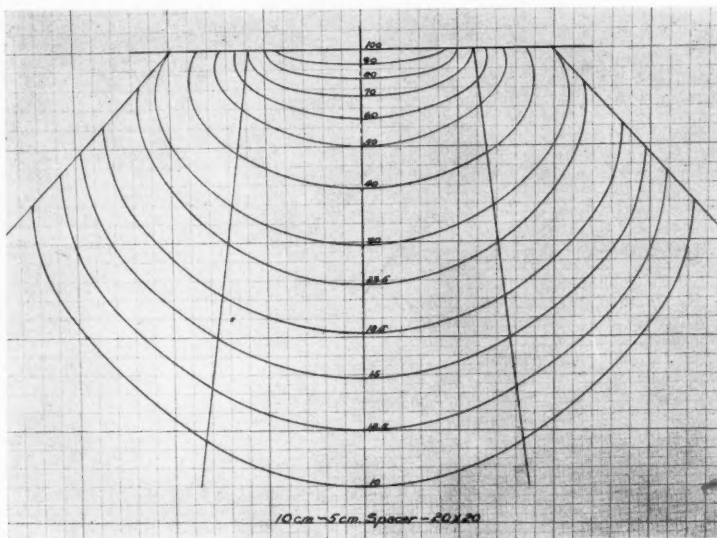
Isodose curve for 4 gm. radium pack with 1 mm. Pt filtration, 3 mm. brass, R.S.D. 15 centimeters. Field size 20×20 centimeters. Depth dose at 10 cm., approximately 30 per cent. Tables for practical dosage can be made for teleradium therapy as for 200 K.V., 0.5 mm. Cu, X-ray (6). From paper to be published by M. C. Reinhard and H. L. Goltz.
